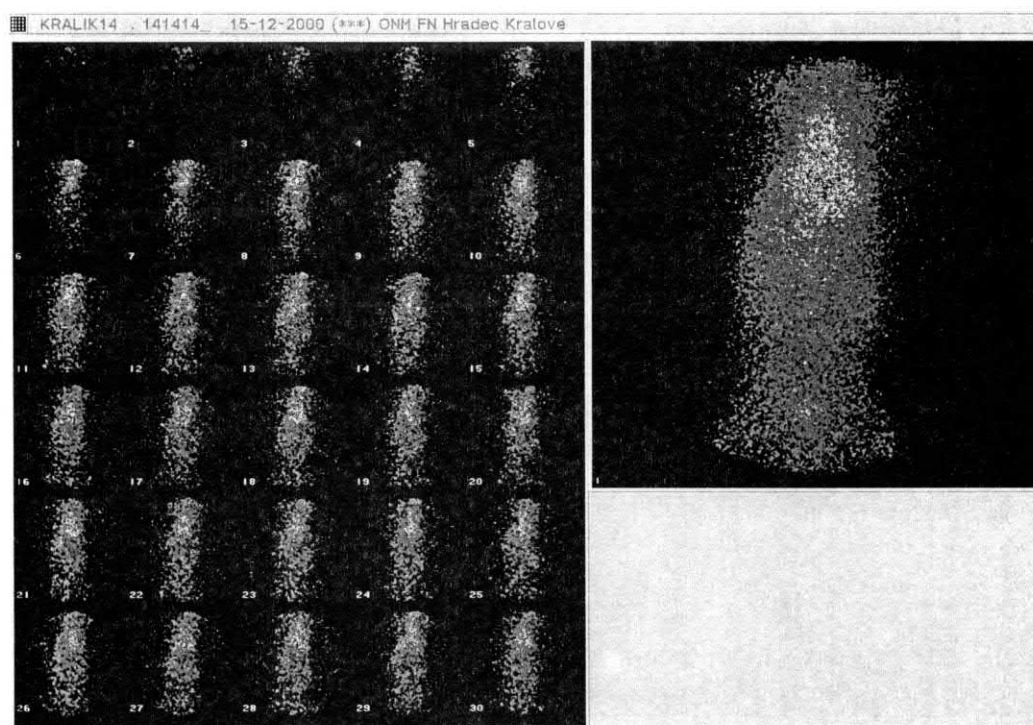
^{131}I -docetaxel administered into the jugular vein (dynamic scintigraphy 0–5 min. pictures no. 1–30, static mode 5.–12. min - see right big picture)
